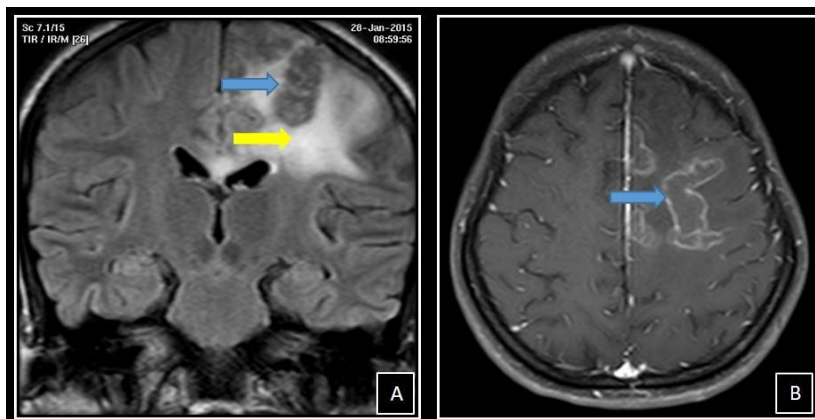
CNS Tuberculosis A: FLAIR coronal B: Post-contrast T1.
